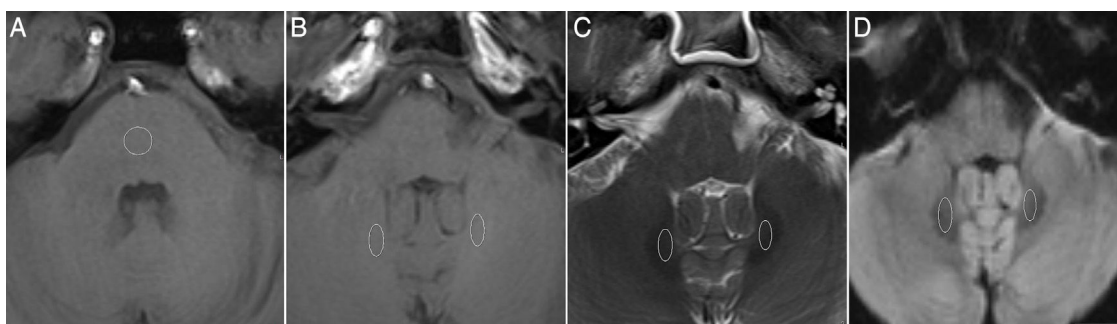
Axial unenhanced T1-Weighted images at the level of the pons (a) and dentate nucleus (b) showing ROI placement. Axial T2-weighted (c) and diffusion weighted (d) images were used to guide the correct ROI placement.
